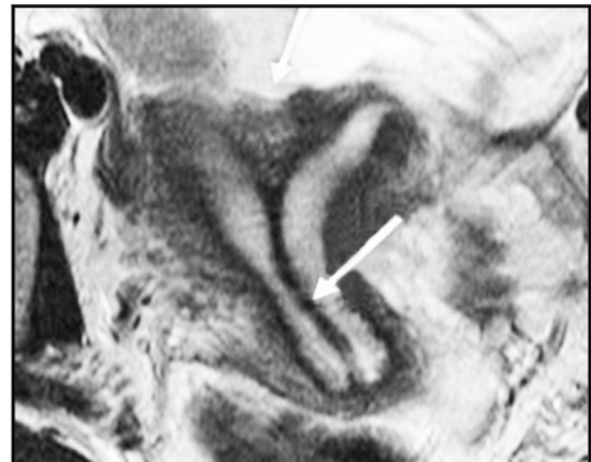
MRI of complete septate uterus
